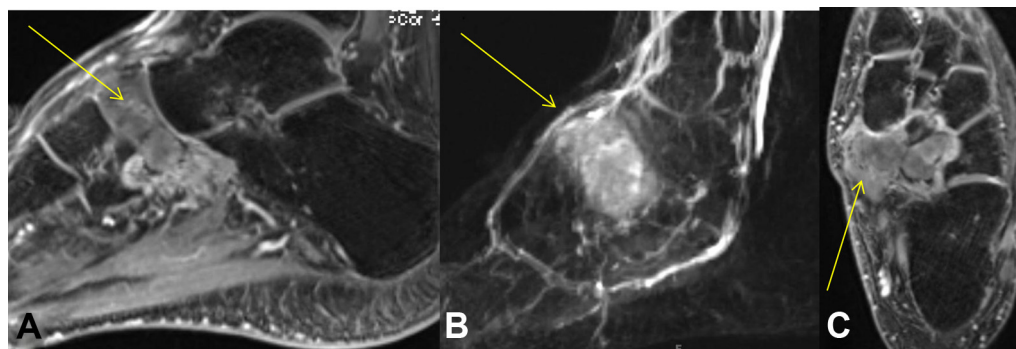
Contrast enhanced magnetic resonance imaging of left foot navicular bone, 14-months post foot/ankle trauma; sagittal view (A), fat saturated images in sagittal view (B), and axial view (C), demonstrated a "fragmented navicular bone, with 0.5 cm focus of nonviable bone; continued abnormal signal within the remaining fragmented navicular, with enhancement on post contrast. Imaging features more suggestive of infection rather than osteonecrosis. Tumor considered unlikely" (yellow arrows).
